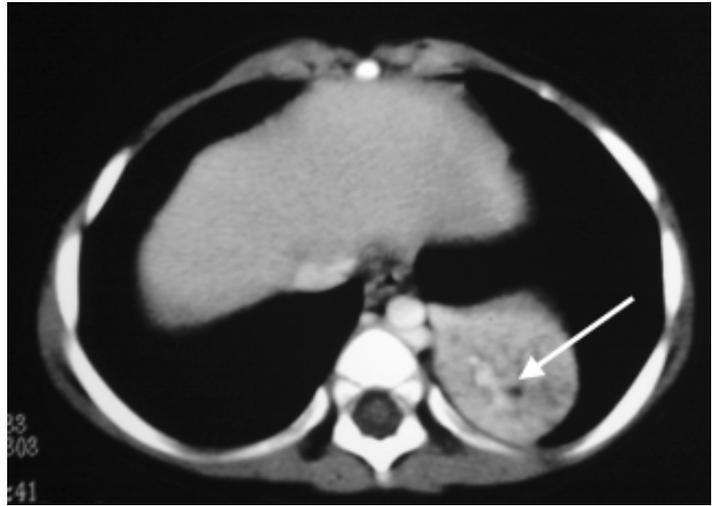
Contrast CT scan of thorax showing heterogenous mass (arrow) in left lower lobe.
